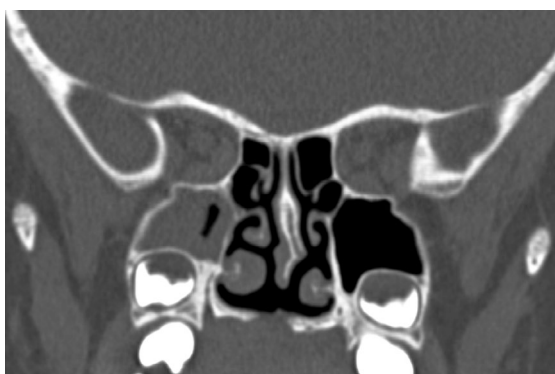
Defect of the hard palate and shortening of the vomer in the coronal projection on computed tomography
